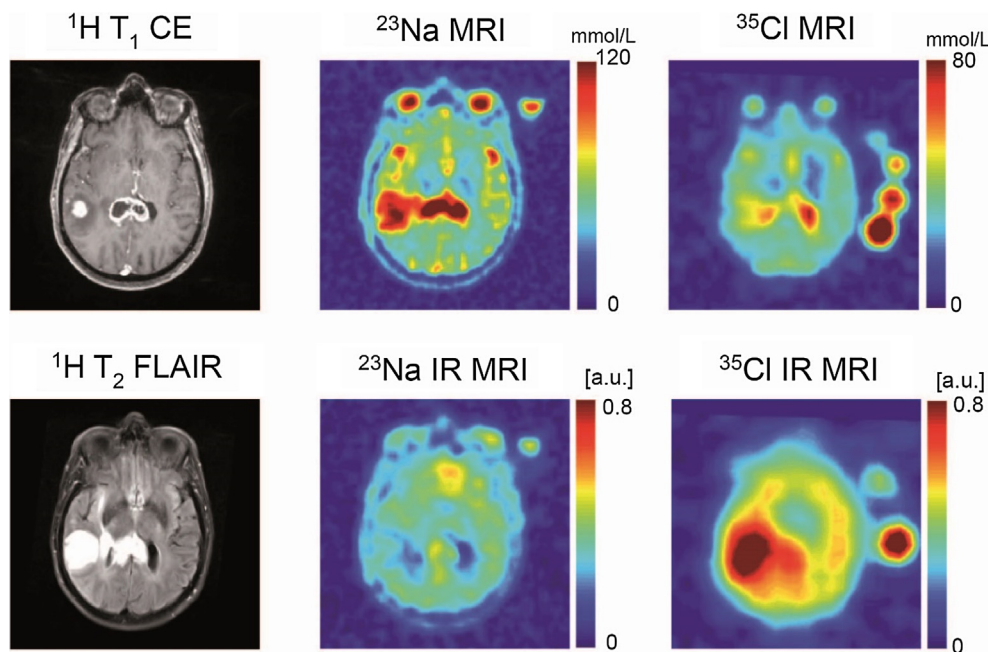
Glioblastoma multiforme of the right temporal lobe and the corpus callosum. 1st column: Contrast-enhanced ^1H T1-weighted (^1H T1 CE) and ^1H T2-weighted fluid-attenuated inversion recovery (IR) (^1H T2 FLAIR) show visualization of contrast-enhancing parts and perifocal edema. 2nd column: Concentration-weighted ^{23}Na MR imaging (^{23}Na MRI) reveals elevated signal intensity in all parts of the tumor, whereas ^{23}Na IR MRI showed parts with reduced and others with increased signal intensities. 3rd column: Slightly increased signal intensities are also visible in concentration-weighted ^{35}Cl MR imaging. In contrast to ^{23}Na IR MR imaging, ^{35}Cl IR MR imaging reveals a strong signal increase in the affected brain region. ^1H images were acquired at 3 T, ^{23}Na and ^{35}Cl images at 7 T. Each ^{23}Na and ^{35}Cl examination required approximately 10 min measurement time. Figure and figure caption adapted from [271]. With permission of the Radiological Society of North America (RSNA).
